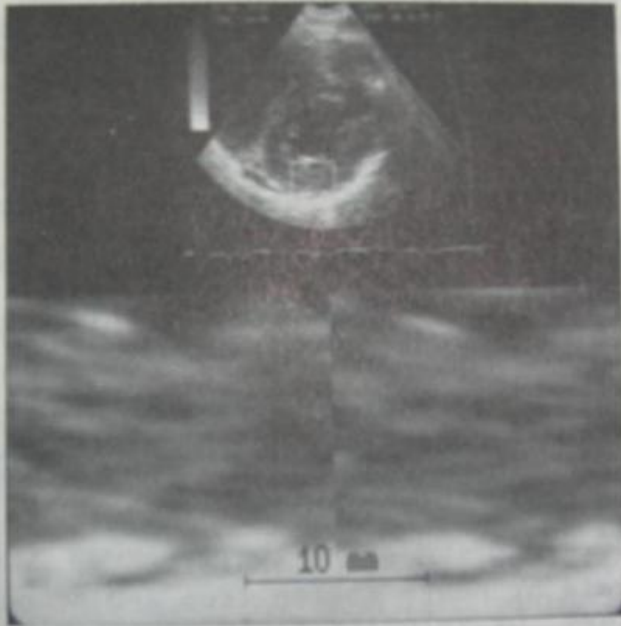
A typical echocardiographic image (short axis view) and two successive frame ROI after lowpass filtering near end-diastole.
